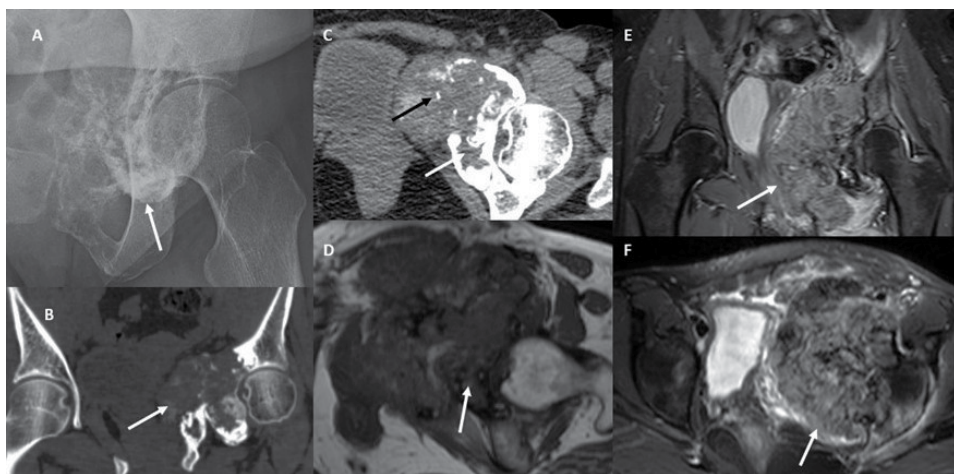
Chondroblastoma: Frontal radiographic view of the left pelvis (A) shows a calcified mass of the left ischium and pubic bones. Coronal bone window (B) and axial soft tissue window (C) images demonstrate an expansile osteolytic lesion (white arrows) with a well-defined lobulated margin and chondroid matrix (black arrow). Chondroblastoma demonstrates a hypointense T1 signal (white arrow; D) with a peripheral sclerotic rim. Coronal (E) and axial (F) T2-weighted fat-saturated images reveal heterogeneous hyperintense T2 signal of the mass (white arrows) with extensive peritumoral edema.
